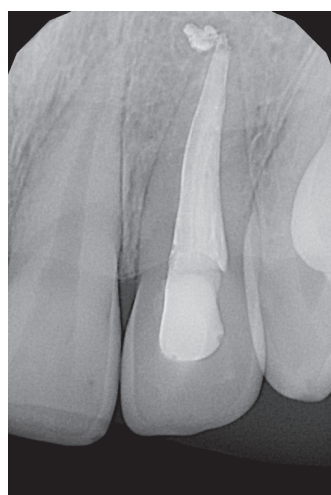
X-ray after 7 years after root canal treatment
